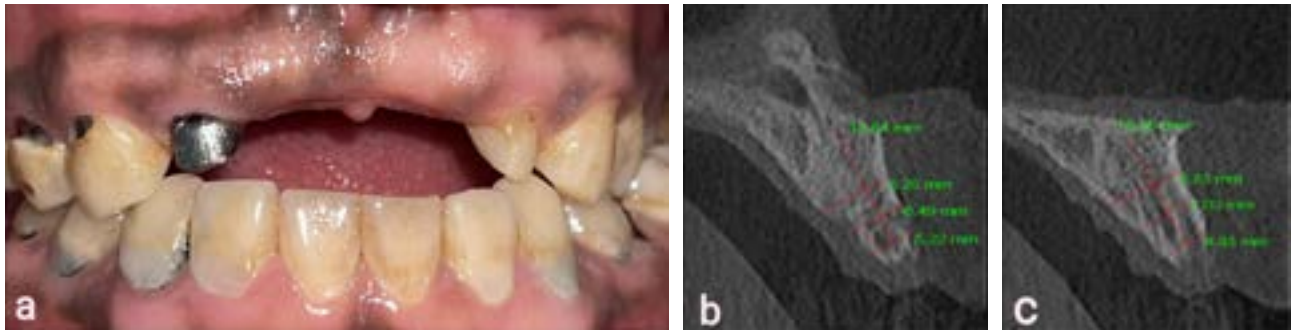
(a,b,c): Preoperative clinical photograph showing frontal view and CBCT scan showing the ridge dimension buccolingually wrt 11 and 21.
